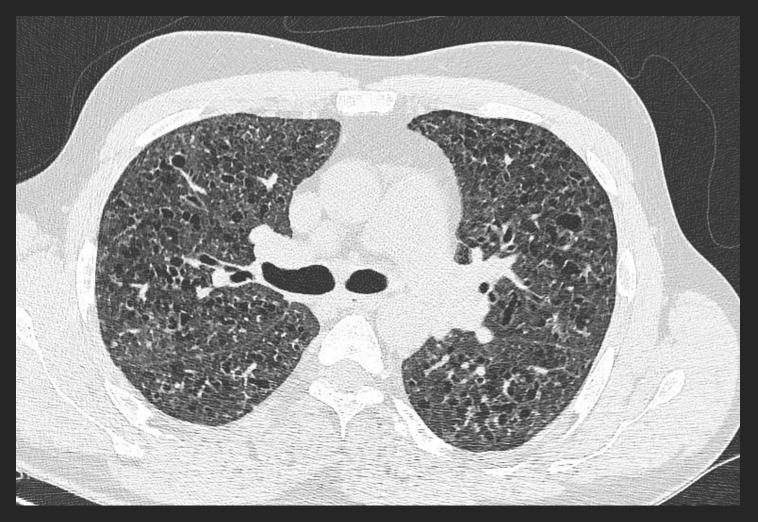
Pulmonary Langerhans cell histiocytosis. CT through the upper lungs shows a characteristic combination of thin-walled cysts and poorly defined nodules. Two of the nodules are just beginning to cavitate (arrows); cavitation is thought to be the earliest stage of cyst formation.
